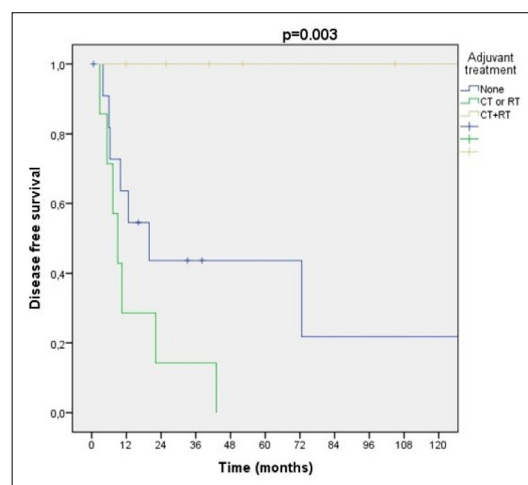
Periods of DFS through adjuvant therapy (CT: chemotherapy, RT: radiotherapy)
